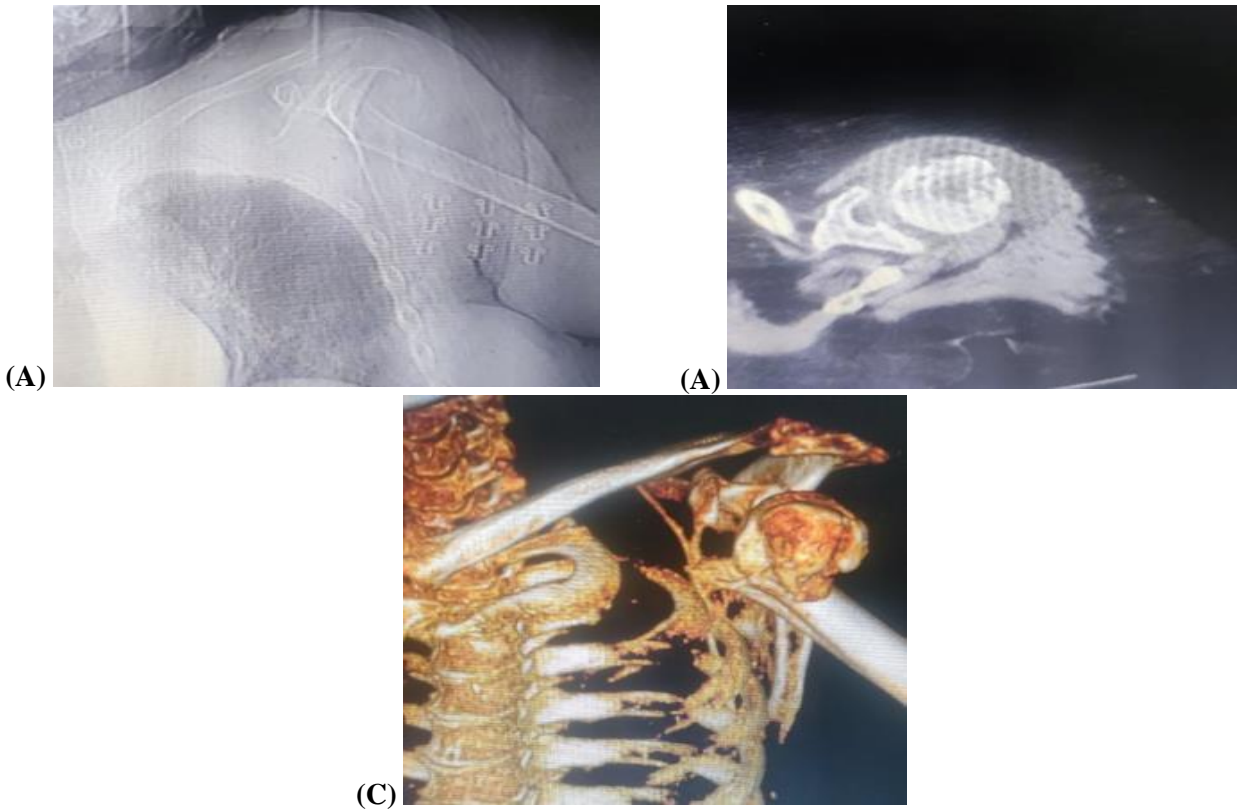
Preoperative (A, B, C) CT showing 4-part proximal humerus fracture. 49 years, fall from height, Diagnosis: Left side 4-part fracture proximal humerus. The patient was admitted to Zagazig University Hospital, Orthopedic ER Department. As for preoperative clinical examination, the patient was neurovascular intact. The patient was operated upon after 2 days by Modified MIROS under C-arm imaging. Postoperative clinical examination showed that the patient was neurovascular intact. Radiological follow up was done until fracture union and pins removal at 8 weeks. Clinical evaluation was done using the CS. The patient was graded as good result
